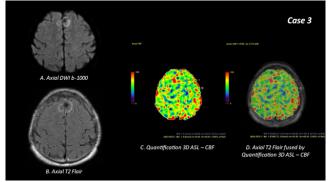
Male, 68 years old has diagnosed with tumor (evaluation after treatment); (A) Axial DWI b-value 1000; (B) Axial T2 Flair; (C) Quantification 3D ASL – CBF; (D) Axial T2 Flair fused by Quantification 3D ASL – CBF
